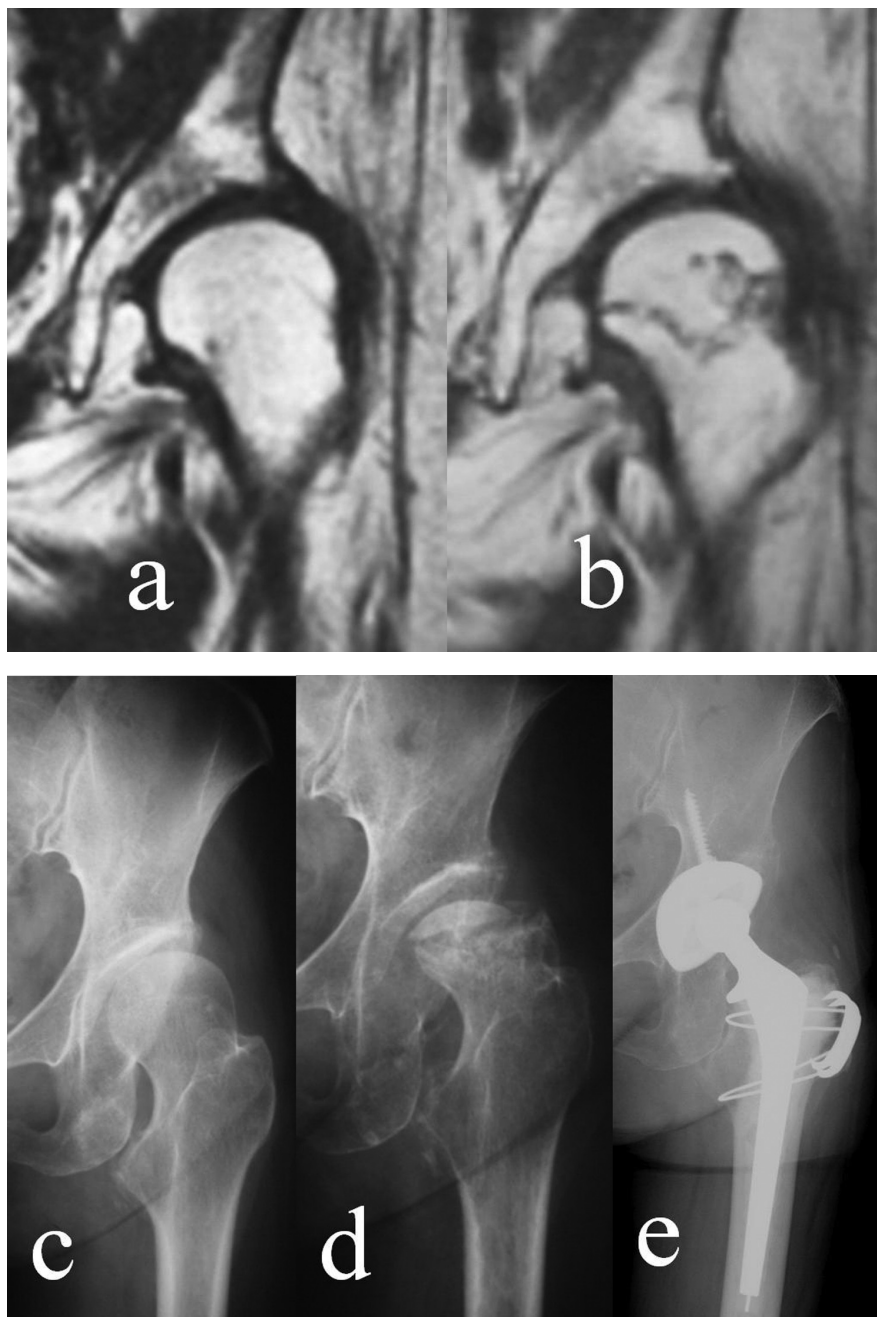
A 57-year-old female with a history of developmental dysplasia of the hip in the left hip. She had received corticosteroids for SLE for 12 years. Simple x-ray imaging and MRI of the left hip showed no evidence of osteonecrosis of the femoral head (a, c). However, osteonecrosis appeared in the left hip 6 months after corticosteroid dosing was increased to 60 mg/day due to SLE recurrence (b). Osteonecrosis of the left hip was large (type C2) and was collapsed 3 months later (d). She underwent total hip arthroplasty 1 year later (e).
